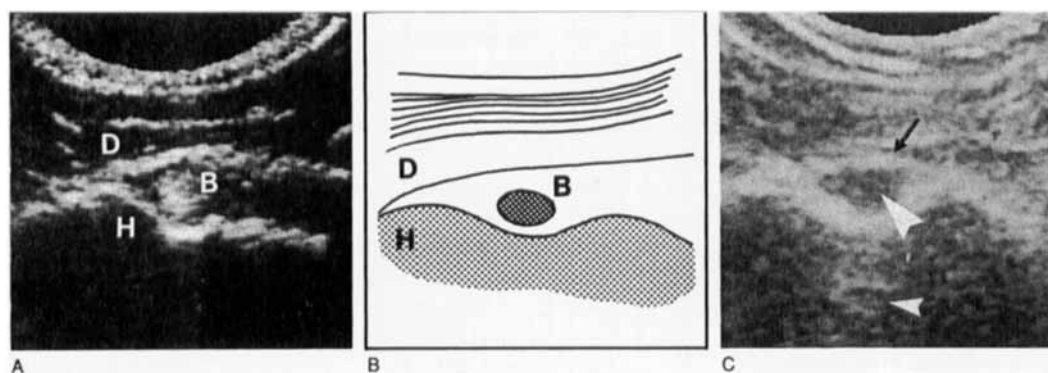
A and B. Normal transverse sonogram showing humerus (H) with bicipital groove, hyperechoic biceps tendon (B) and overlying deltoid muscle (D). C. Hyperechoic tendon sheath (black arrow) and slightly enlarged hypoechoic cross section of biceps tendon (large arrowhead). Small arrowhead shows reverberation artifact.
